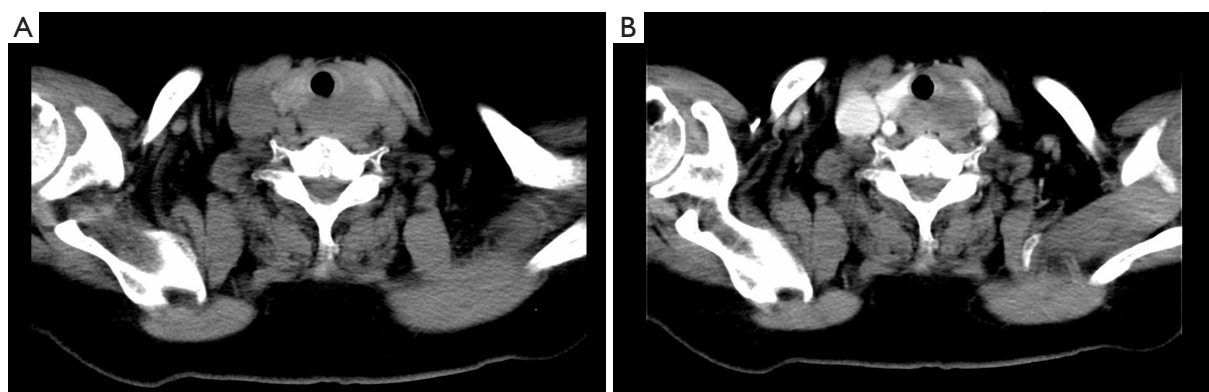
CT images of tracheal adenoid cystic carcinoma with thyroid invasion. (A,B) CT shows a low-density mass in the left lobe of the thyroid, with unclear boundaries with the trachea and esophagus, and heterogeneous mild enhancement. CT, computed tomography.
